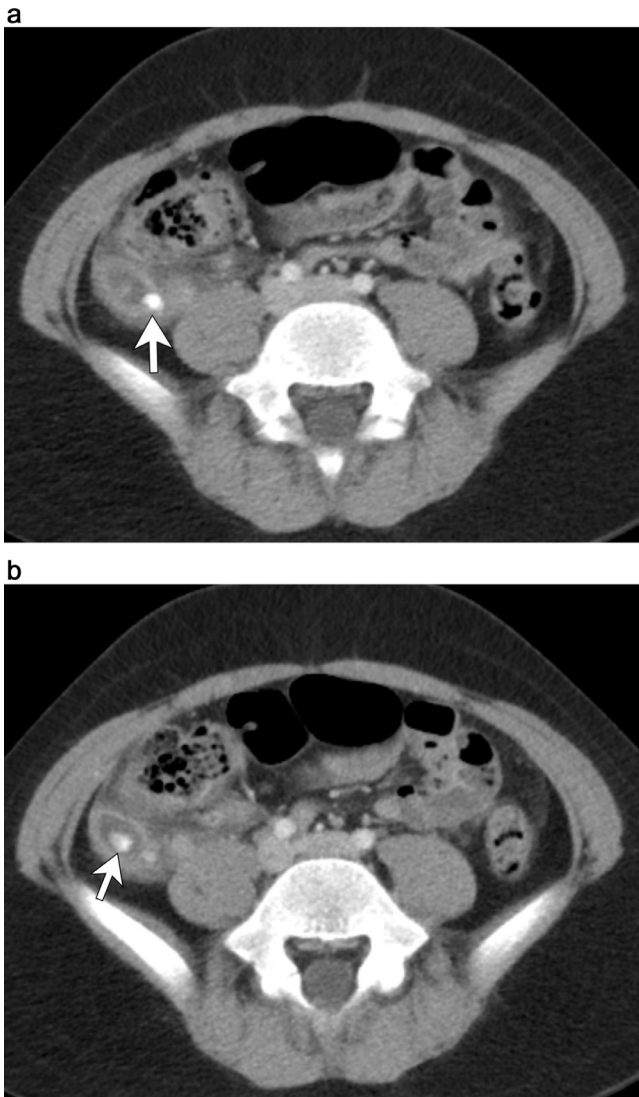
A 10-year-old boy with acute appendicitis. a, b. Initial, contrast-enhanced axial CT images of the pelvis demonstrate 2 calcified appendicoliths (arrows) within an enlarged, fluid-filled appendix with surrounding inflammatory changes.
